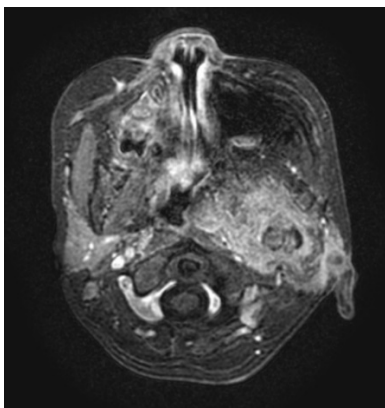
The MRI imaging in axial T1 (left) and axial postcontrast (right) at time of diagnosis
